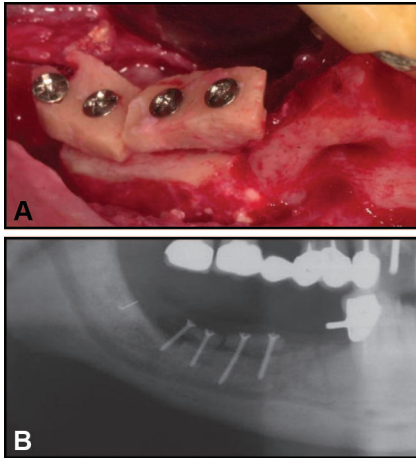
Clinical (A) and radiographic (B) views of the second tier bone block placement following fixation in the recipient site.
